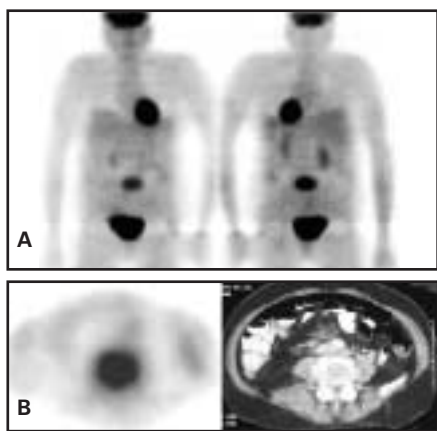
Intense FDG accumulation is present in a case of lower lumbar spine osteomyelitis. Maximum intensity projection (A), transaxial FDG-PET and CT images (B).
